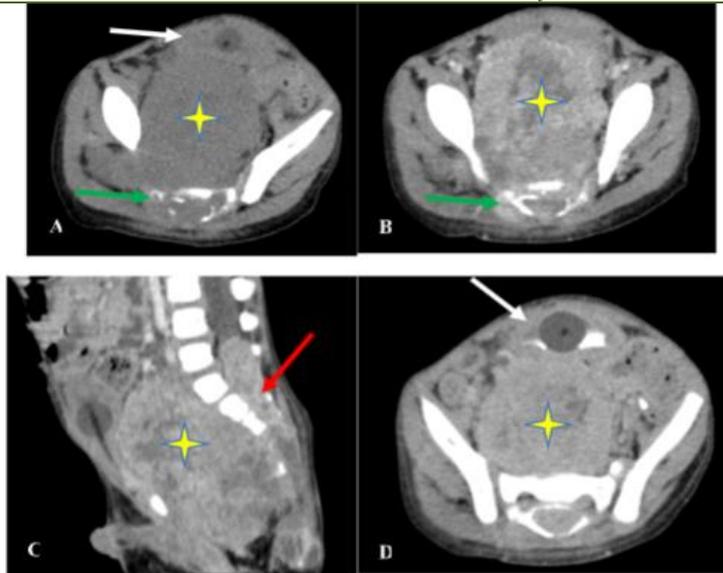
Axial image (A) of abdomino-pelvic CT scan without contrast, axial (B) and coronal (C) images with contrast in venous phase and excretory phase (D) showing a centropelvic mass (stars), with involvement of the sacrococcygeal region, predominantly solid with delineated cystic areas, heterogeneous enhancement following contrast injection. This mass is causing mass effect on the catheterized bladder (white arrows) and a sacrococcygeal bone lysis (green arrows) with endocanal extension (red arrows)
